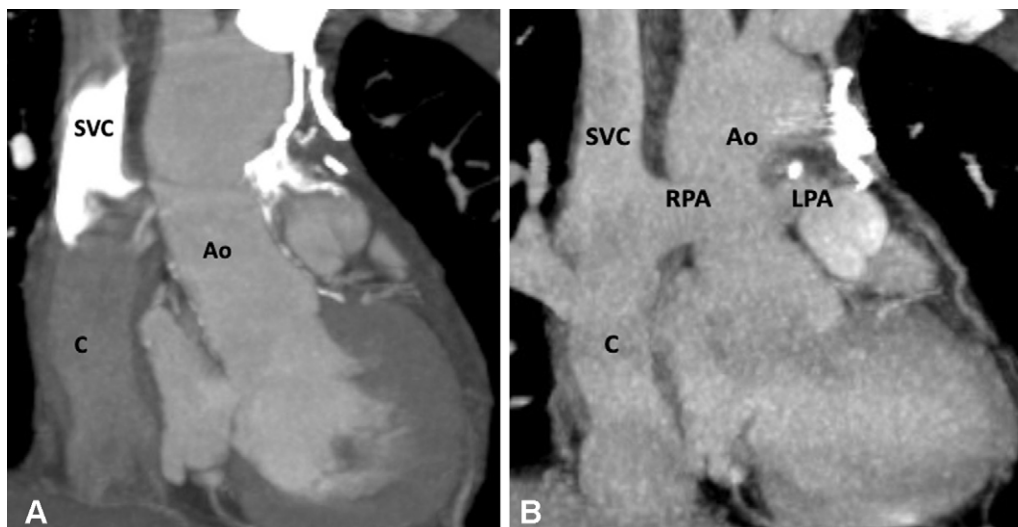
Extracardiac Fontan procedure biphasic acquisition protocol. (A) Coronal reformatted maximum intensity projection (MIP) CT image in the early arterial phase shows well-opacified aortic root. The Fontan circuit is not opacified, giving false impression of thrombosis. (B) Coronal reformatted MIP CT image in the late venous phase shows uniform opacification of the Fontan conduit. Ao = aorta, C = conduit, LPA = left pulmonary artery, RPA = right pulmonary artery, SVC = superior vena cava.
